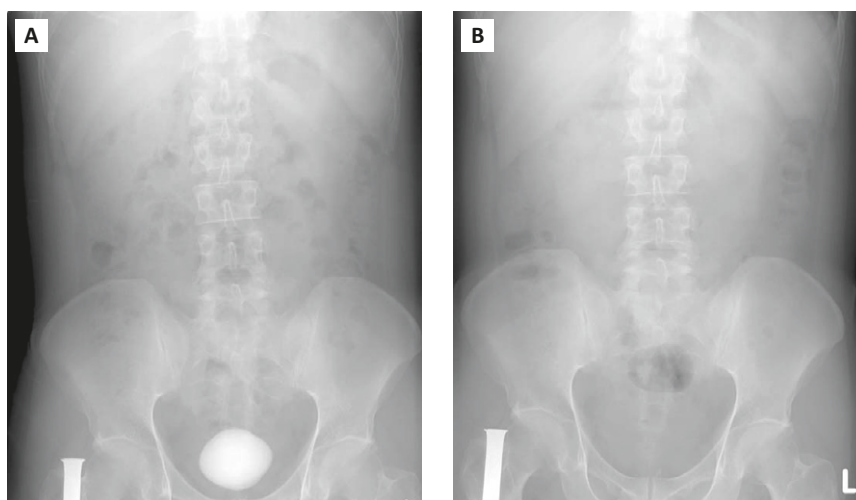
A plain X-ray. (A) A giant pelvic stone is shown. (B) No bladder stones were observed 2 months later.
